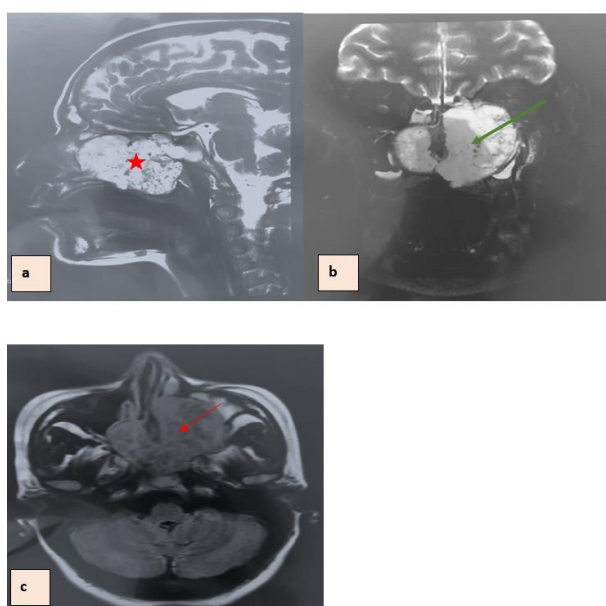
An orbital MRI in sagittal (a) and axial (b, c) section: Showing a heterogeneous expansive process with irregular contours. The process invaded the ethmoidal cells, the left maxillary sinus, infratemporal fossa and parapharyngeal space (red color arrow), prolapsed into the nasolabial and oropharyngeal lumen. It exhibited heterogeneous hyposignal T1(c), hypersignal T2 (a, b). The MRI showed invasion of the It destroyed the nasal septum in its posterior part, the sieve blade, the posterior part of the hard palate (red color star) and left endorbital extension (green color arrow).
